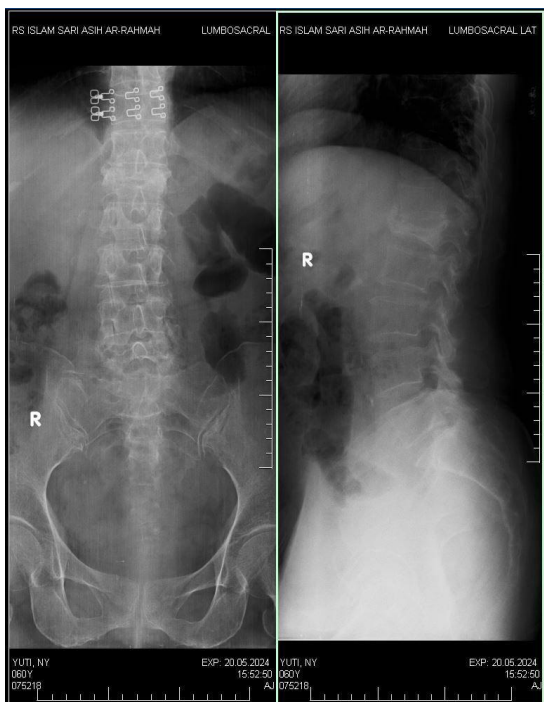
Early lumbar X-ray (before receiving medical rehabilitation program)
